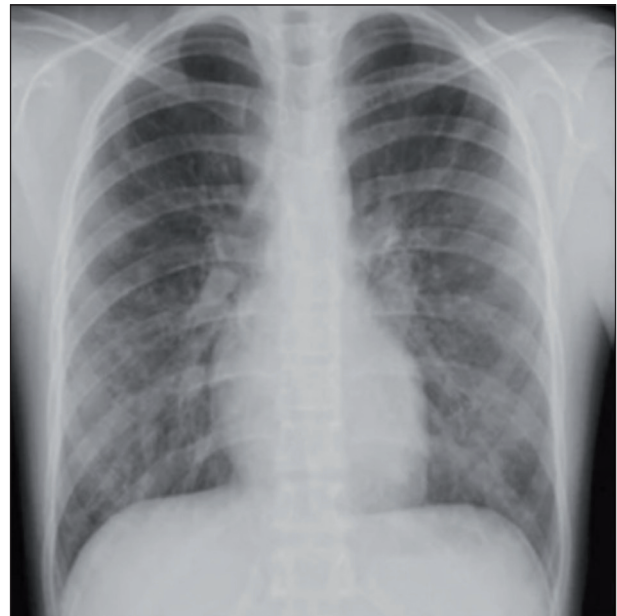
Chest X-ray with bilateral infiltrates.
